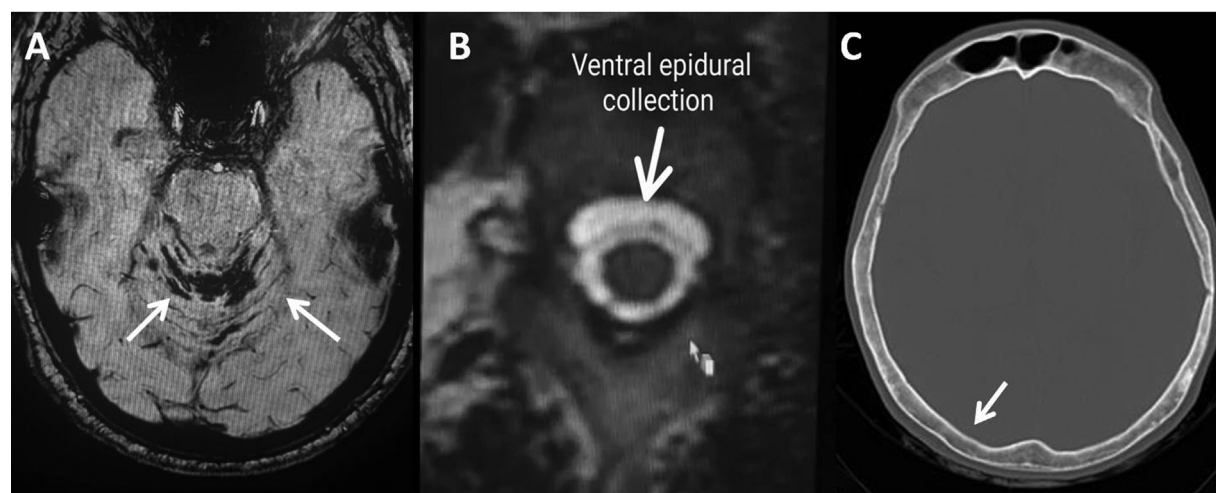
Imaging findings indicating chronicity of spontaneous intracranial hypotension. (A) Axial susceptibility-weighted image of the brain showing blooming in the region of bilateral cerebellar folia, suggesting superficial siderosis (arrows). (B) Axial T2 weighted image of thoracic spine showing rounded spinal epidural collection in the anterior aspect. (C) Axial plain computed tomography bone window of the head showing thickened cortex (arrow).
